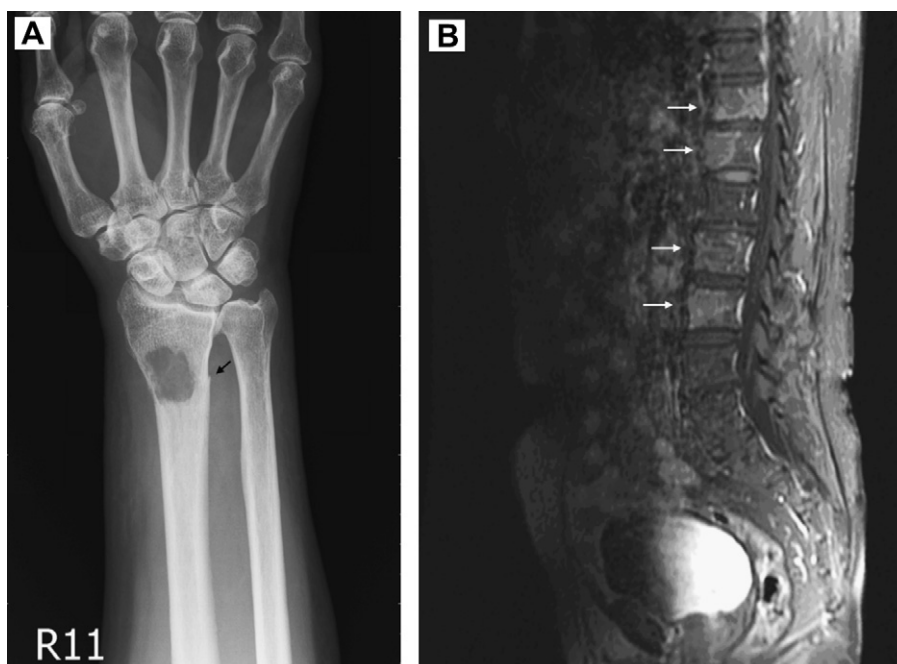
Images of case 1. (A) One pure osteolytic lesion is clearly visible at the right distal radius with a pathologic fracture (black arrow) (plain film). (B) The magnetic resonance image of lumbar spine reveals discrete lesions at the T11, T12, L2 and L3 vertebral bodies, as indicated by the white arrows.
